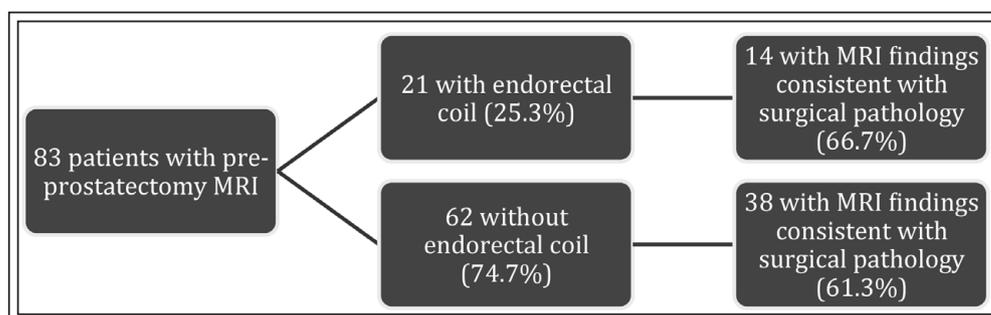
Consistency of MRI findings with final surgical pathologic staging.
